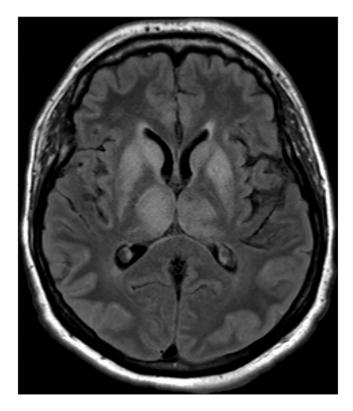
Axial FLAIR MRI image showing confluent hyperintense signal abnormality involving the bilateral thalamus, caudate and putamen.
